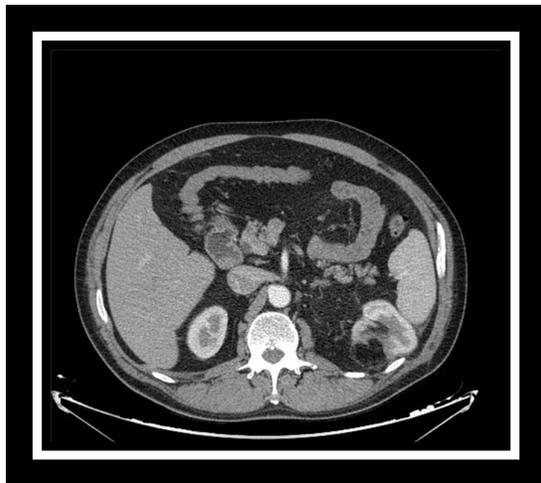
Cross sectional computed tomography image six months after partial nephrectomy
